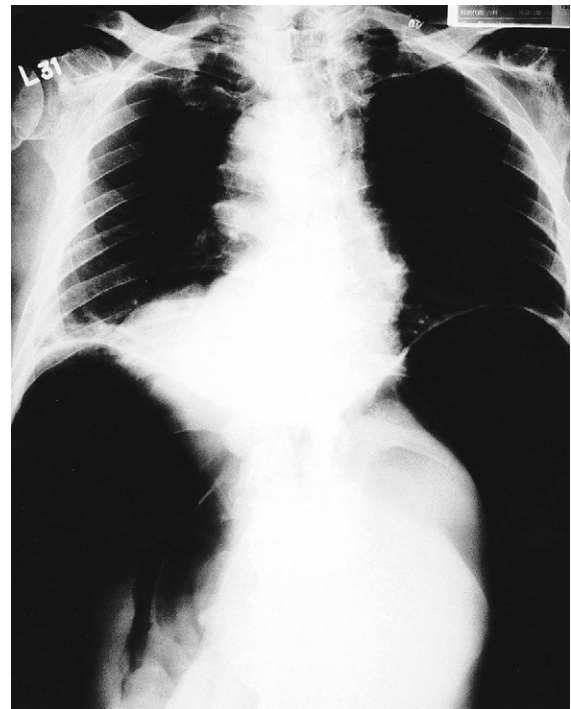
Chest radiograph shows massive sub-diaphragmatic air with centralized internal organs after upper gastrointestinal endoscopy.
